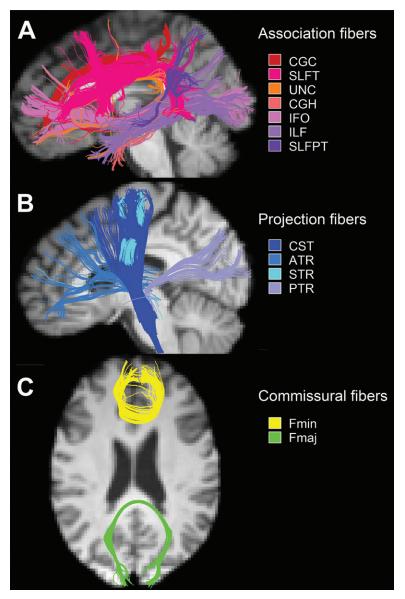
Three orthogonal views of 13 preselected white matter tracts acquired with automated atlas-guided tract reconstruction. *A*, MRI scan shows long association tracts for cingulum of cingulate gyrus (CGC), hippocampal part of cingulate gyrus (CGH), fronto-occipital fasciculus (IFO), inferior longitudinal fasciculus (ILF), parietal part of superior longitudinal fasciculus (SLFPT), temporal part of superior longitudinal fasciculus (SLFT), and uncinate fasciculus (UNC). *B*, MRI scan shows projection tracts for cortico-spinal tract (CST), anterior thalamic radiation (ATR), posterior thalamic radiation (PTR), and superior thalamic radiation (STR). *C*, MRI scan shows commissural tracts for forceps major (Fmaj) and forceps minor (Fmin).
